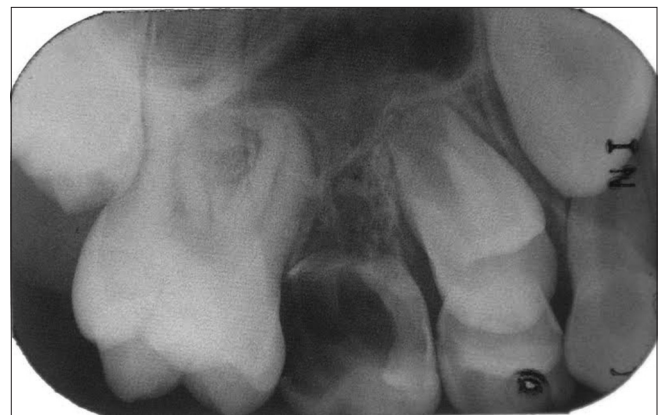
Intraoral periapical radiographs of maxillary right second deciduous molar showing the hypoplastic and hypomineralized crown with wide pulp chamber and root canal
